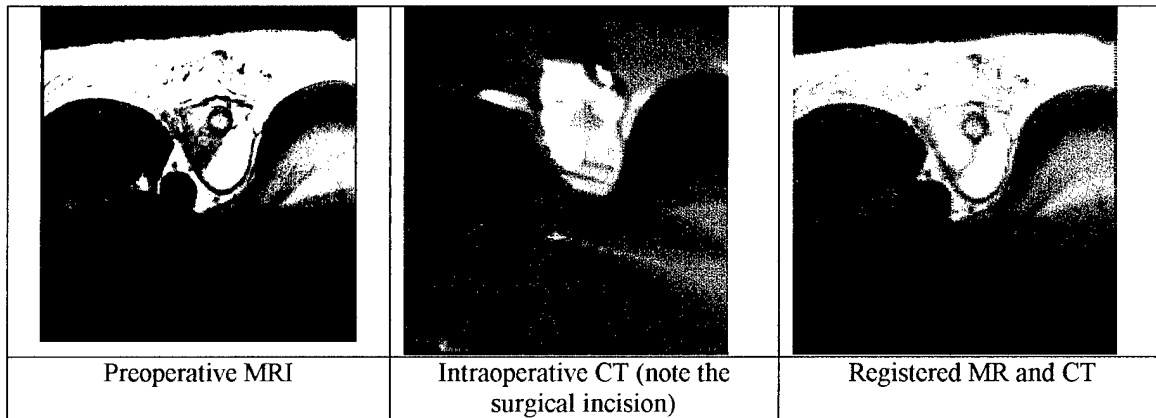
Preoperative MRI and Intraoperative CT Registration
